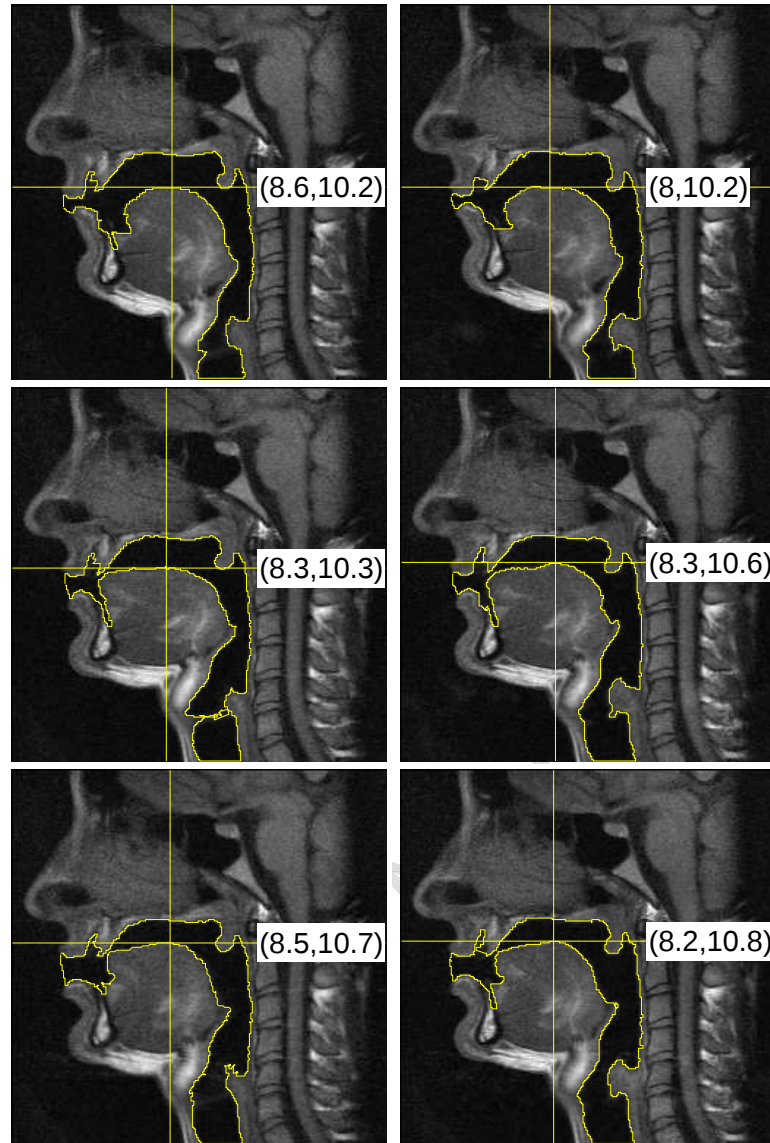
Midsagittal MRI images with superimposed contour relative to EP fricative sounds. At the top row the labiodental fricatives [f] and [v]; at the center the alveolar fricatives [s] and [z] and at bottom the palatoalveolar fricatives [ʃ] and [ʒ]. All were sustained having an example word with the fricative at the beginning and followed by the oral vowel [a].
